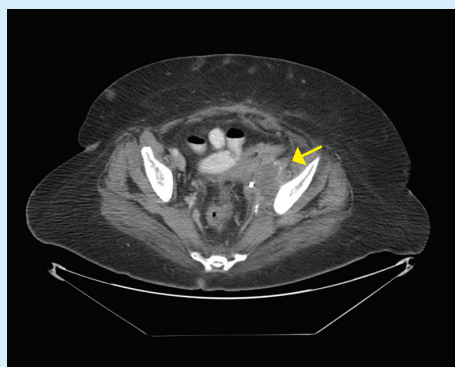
Axial CT showing left pelvic mass (arrow). The mass abuts courses of the left femoral, sciatic, and obturator nerve.
